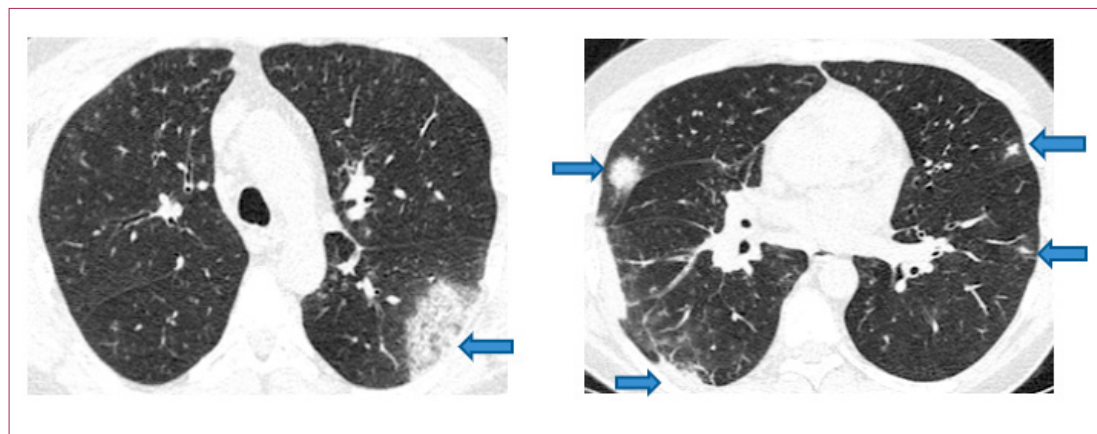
Multiple infiltration areas in the HRCT of the patient
